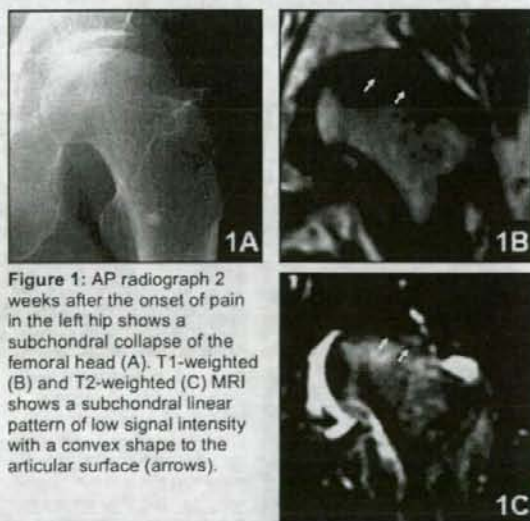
AP radiograph 2 weeks after the onset of pain in the left hip shows a subchondral collapse of the femoral head (A). T1-weighted (B) and T2-weighted (C) MRI shows a subchondral linear pattern of low signal intensity with a convex shape to the articular surface (arrows).
